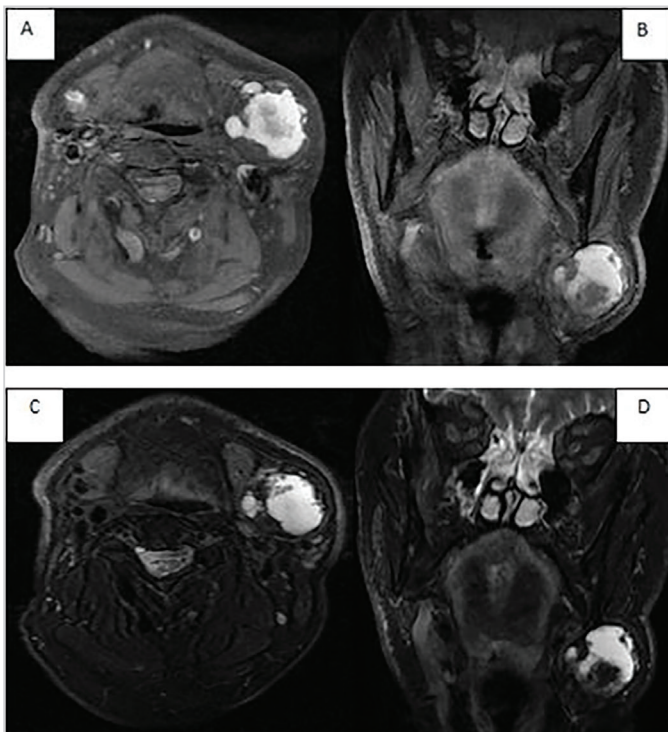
Contrast-enhanced MRI images of the mass in the left submandibular area (A: T1 axial, B: T1 coronal; C: T2 axial, D: T2 coronal)
